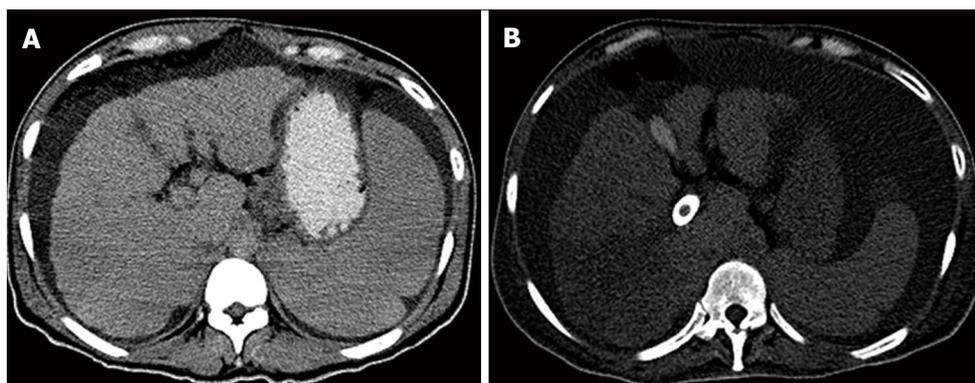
Abdominal computed tomography evaluation. A: Abdominal CT scan one year prior to TIPS placement showing a small nodular liver with ascites and splenomegaly; B: Abdominal CT scan one day after TIPS placement showing a hypodense triangular-shaped heterogeneous area in the right posterior segments of the liver, suggestive of hepatic ischemia; note how the spleen size is significantly reduced.
